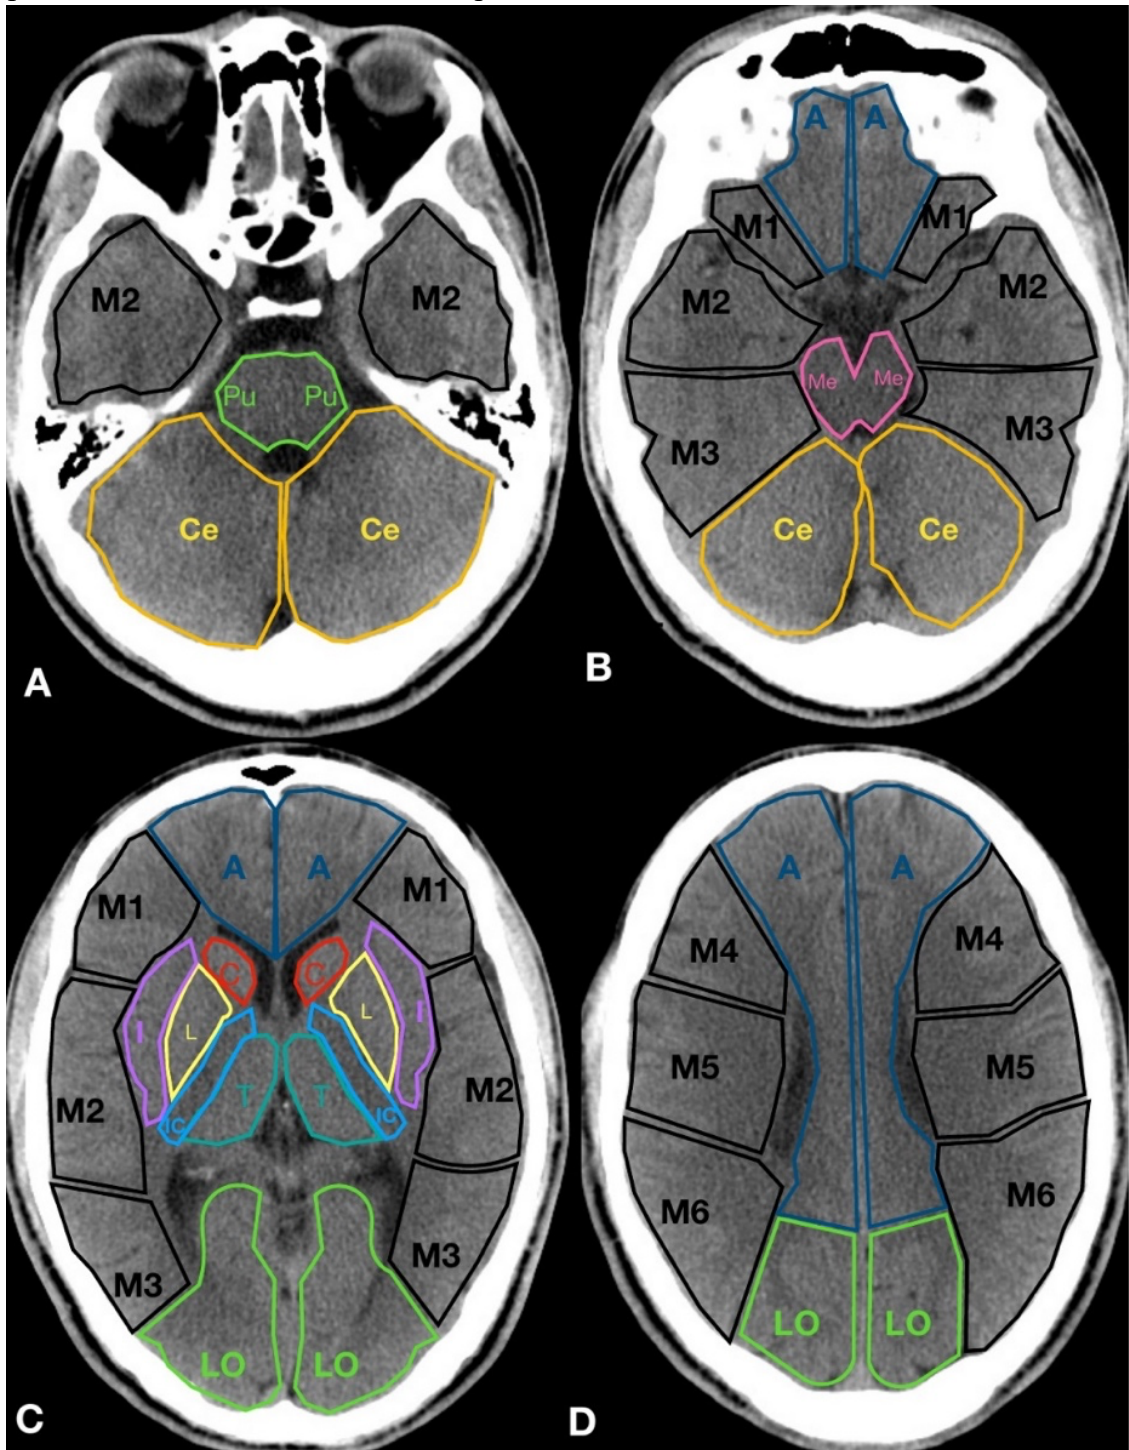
“Whole brain” - ASPECTS score for the whole brain.
